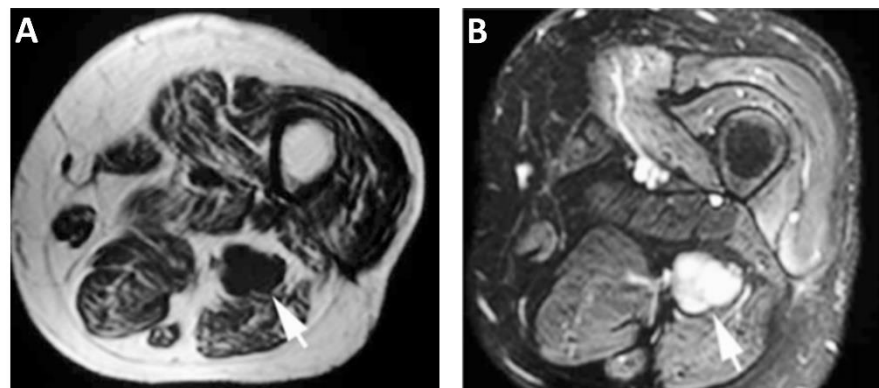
Transverse MRI slice at distal residual limb of an individual with an above knee amputation to investigate pain (a sciatic neuroma shown by arrow was observed) implementing A: T1 weighting, giving high contrast between adipose and muscle tissues, and B: T2 weighting, giving high signal in fluid-filled and inflamed [191]
